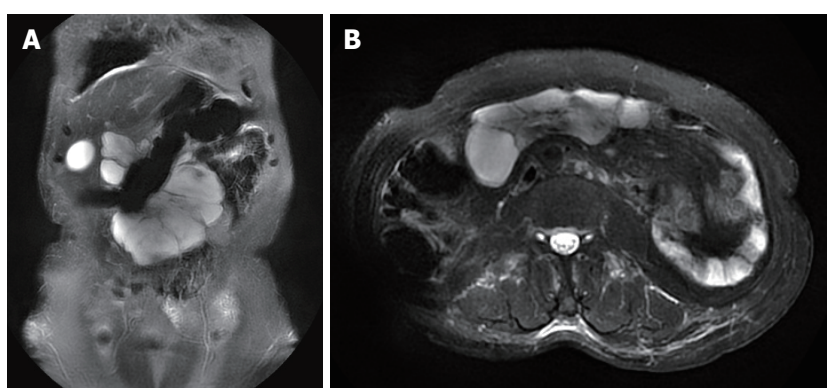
Abdominal magnetic resonance imaging shows cystic long T1 and long T2 signal masses in the anterior wall of the middle abdomen, 110 mm × 40 mm in size. No abnormal enhancement was observed (Case 4). A: Coronal position; B: Axial position.
